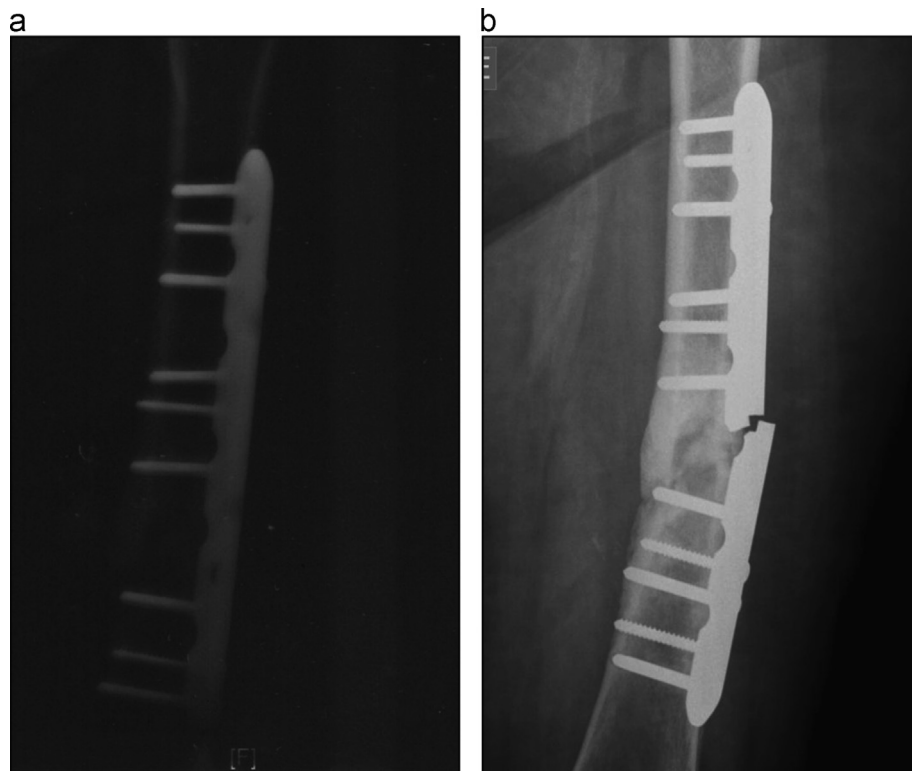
X-Ray image of second LCP: (a) after implantation; (b) after fracture.
